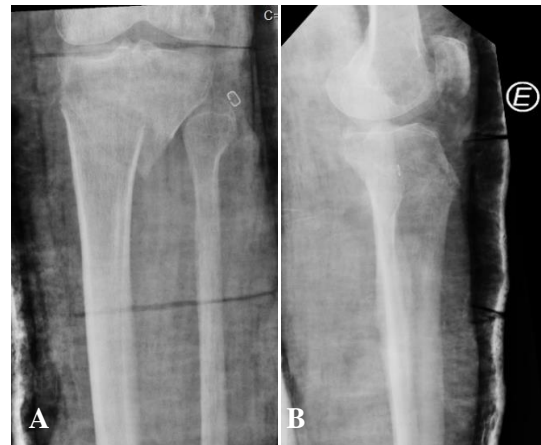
(A) AP radiograph 4 weeks later, it revealed an additional 4 mm lateral displacement, and 3 mm tibial shortening; (B) Lateral radiograph 4 weeks later.
